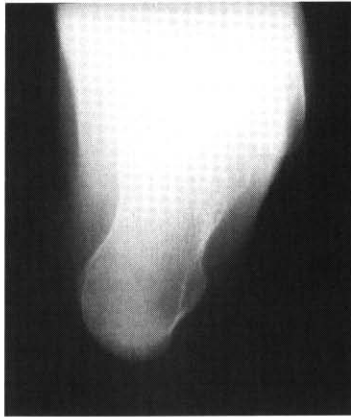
Calcaneal axial radiographic view of rigid hindfoot varus.
